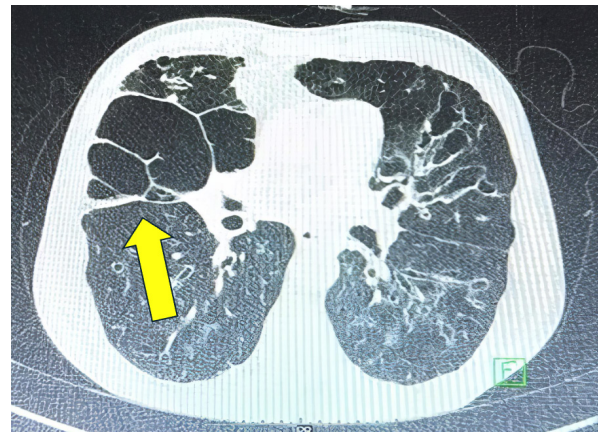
High-resolution computed tomography showing bilateral lung bronchiectasis predominantly in the right middle lobe.
